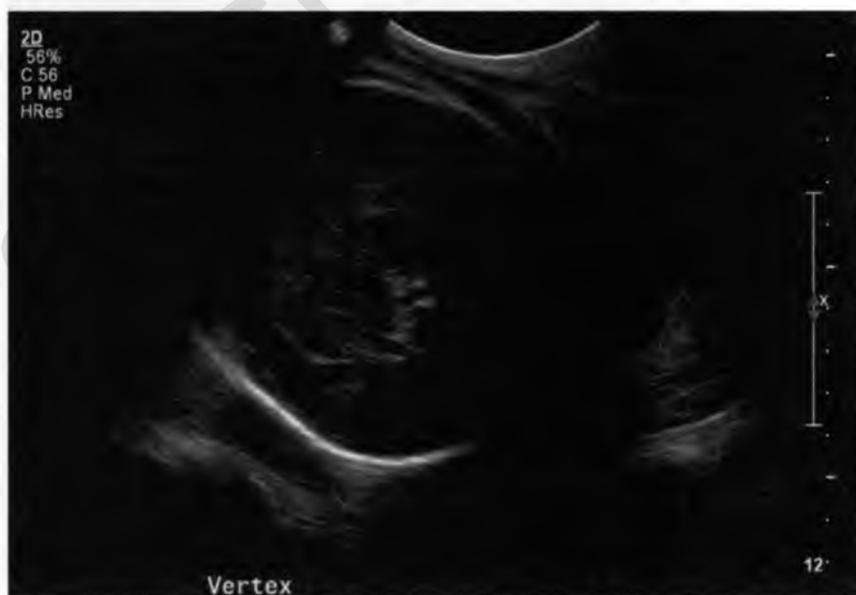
Ultrasound image of cephalic presentation, at term
